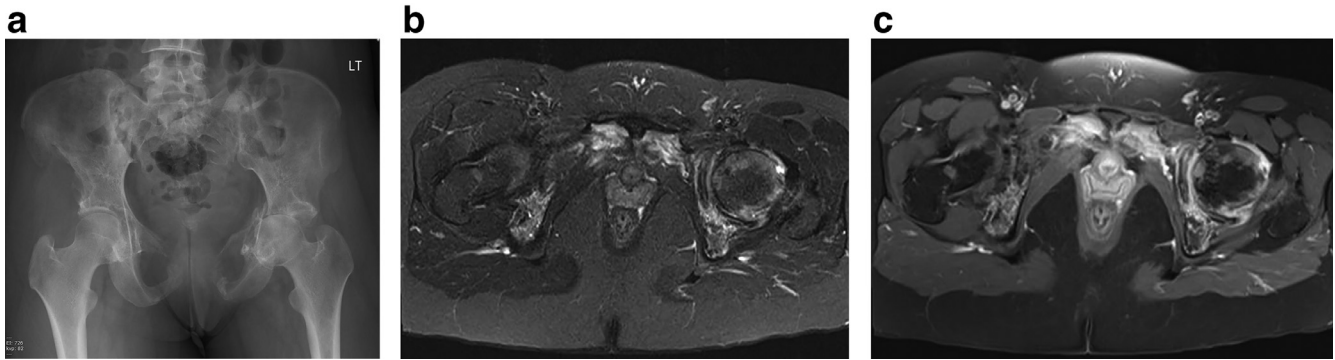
Nineteen-year-old female with Gorham-Stout disease. (a) AP radiograph of the pelvis. There is resorption of the superior and inferior pubic rami bilaterally, with erosive changes also seen in the acetabula and right iliac wing (b) axial T2 fat-saturated (FS) MRI sequence. High signal is seen in the soft tissue surrounding the area of osteolysis, (c) postgadolinium T1 FS MRI. Avid enhancement is seen in the areas of osseous and soft tissue abnormality.
